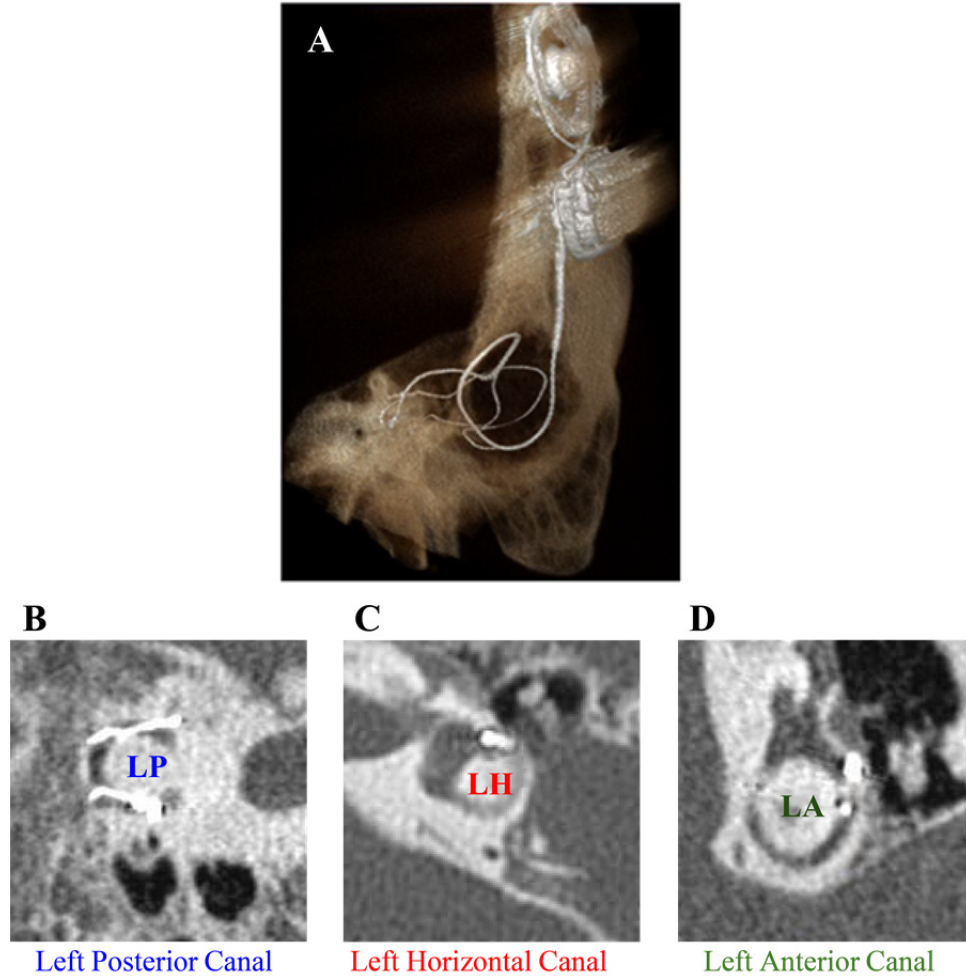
CT Imaging of electrode array positioning in subject MVI002. (A) Post-operative CT 3D reconstruction for subject MVI002 with the stimulator. (C-D) Planar CT images outlining electrode shanks implanted in the (B) left posterior, (C) left horizontal, and (D) left anterior canals.
